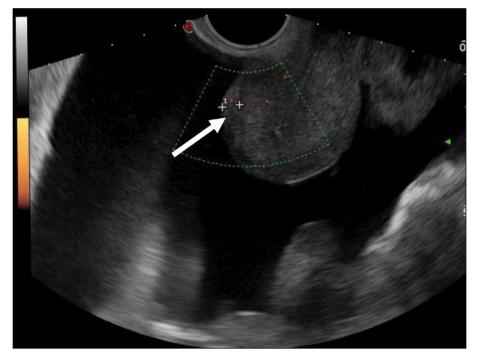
Dopplerography in the energy mode. Malignant struma ovarii. Carcinomatosis of the pelvic peritoneum anterior to the uterus (arrow). The visualized tumor lesion is 6 mm thick.
